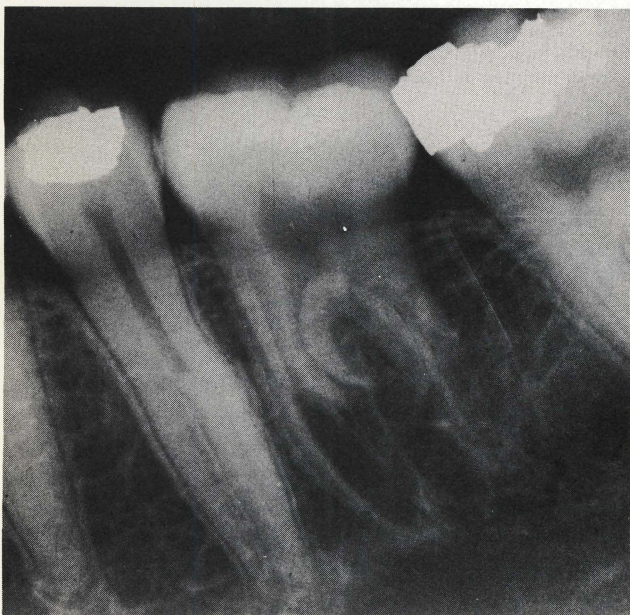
Periapical radiograph of transplanted tooth, immediate postoperative.
